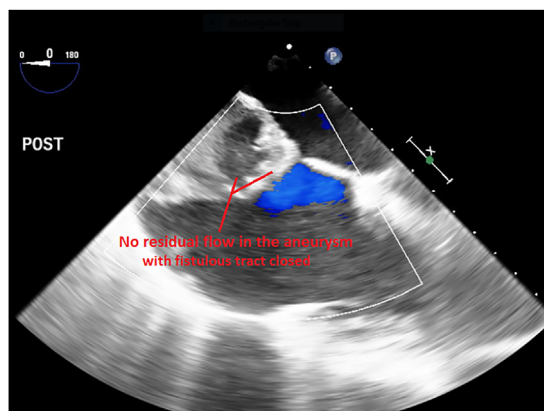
Postoperative transesophageal echocardiogram demonstrating no residual flow into the giant coronary artery aneurysm and no fistulous communication into the right atrium
